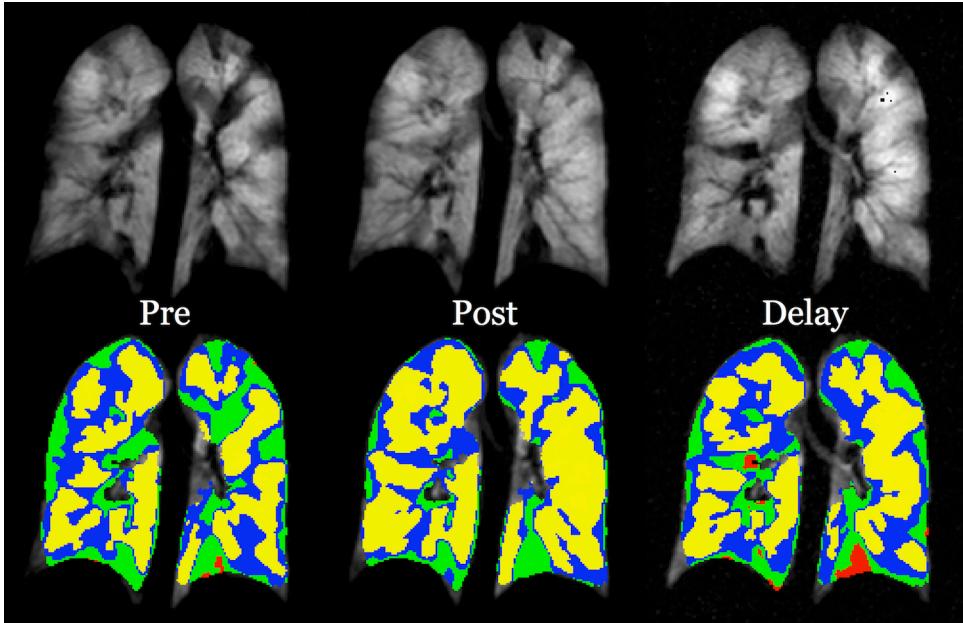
Pulmonary functional segmentation using the algorithmic framework first described in [34] for hyperpolarized  $^3\text{He}$  MRI. These data were taken from a current study looking at the implications in ventilation pre- and post-albuterol intake including an additional acquisition at some delay period following the post-albuterol imaging. The ventilation-based segmentation is as follows: red = no ventilation, green = poorly ventilated, blue = normally ventilated, and yellow = well-ventilated. Note the improvement in both the qualitative assessment of the ventilation map (top) and the corresponding segmentation time course (bottom) followed by an approximate return to pre-albuterol conditions following the delay period.
